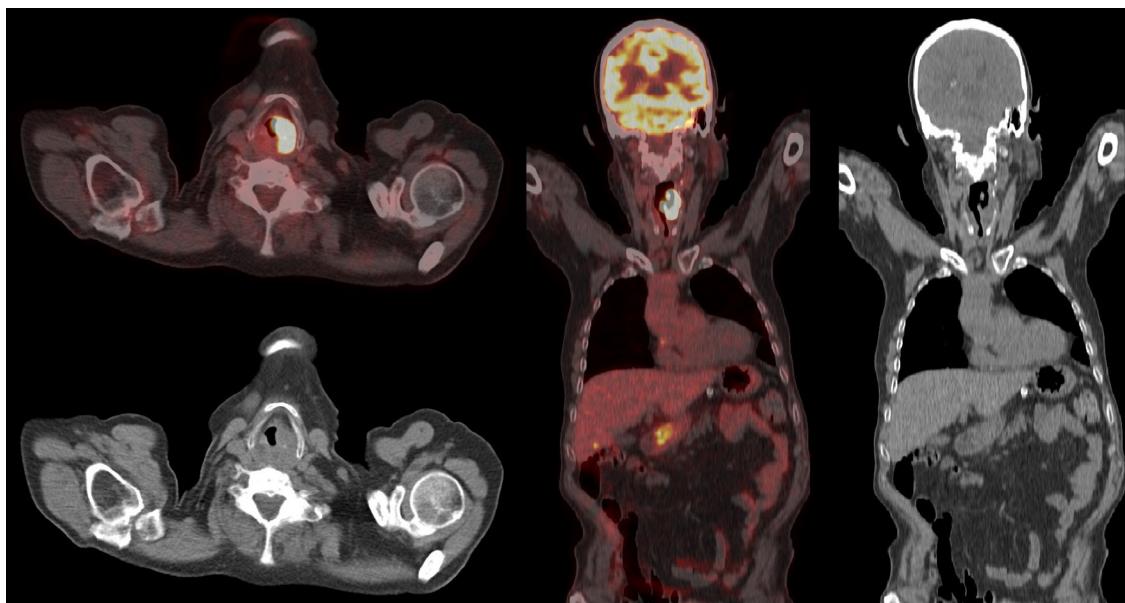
Initial staging using fluorine-18 fluorodeoxyglucose positron emission tomography-computed tomography (18F-FDG-PET/CT) revealed a hypermetabolic lesion with high rate of cell proliferation that extended from the base of the tongue to the left vocal cord, resulting in transmural thickening and slight displacement of the midline (axial and coronal views) with SUVmax: 37.3 (SUV mediastinum: 2.8). An additional hypermetabolic focus left of the transverse processes of D3 and two abdominal para-aortic lymphadenopathies were also observed.
